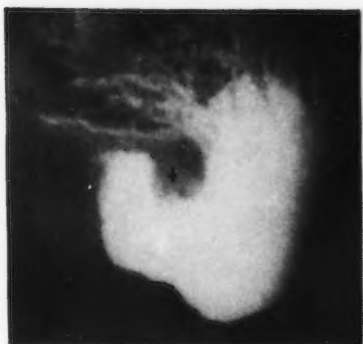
Superficial spreading carcinoma with a peptic ulcer. A. The roentgenogram of the barium-distended stomach discloses a crater shadow on the lesser curvature (arrow). Other projections disclosed a double contour of the apex of the crater.
